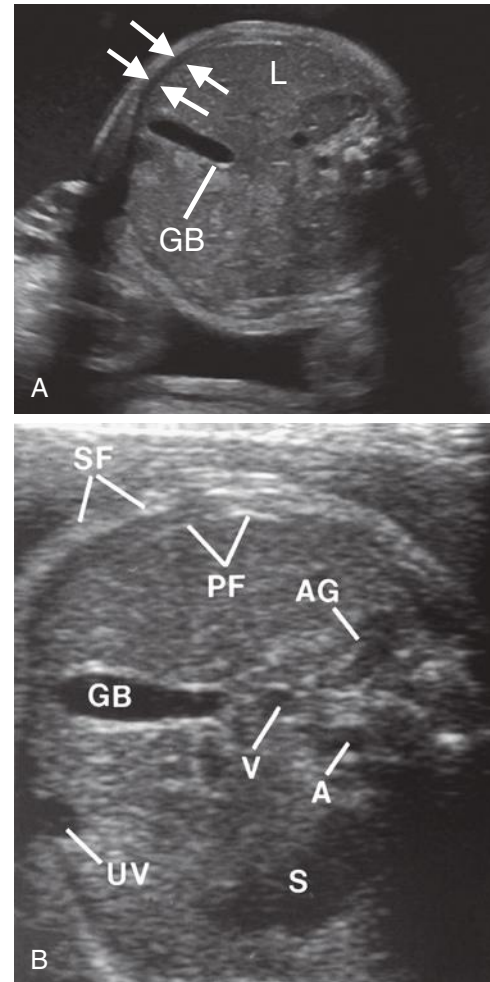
Transverse axial sonograms, fetal abdomen. A, Lucent abdominal wall musculature (arrows) may erroneously give the impression that ascites is present. B, Abdominal wall musculature lies between the subcutaneous fat (SF) and the properitoneal fat (PF). Individual layers can be appreciated. A, aorta; AG, adrenal gland; GB, gallbladder; L, liver; S, stomach; UV, umbilical vein; V, inferior vena cava.
